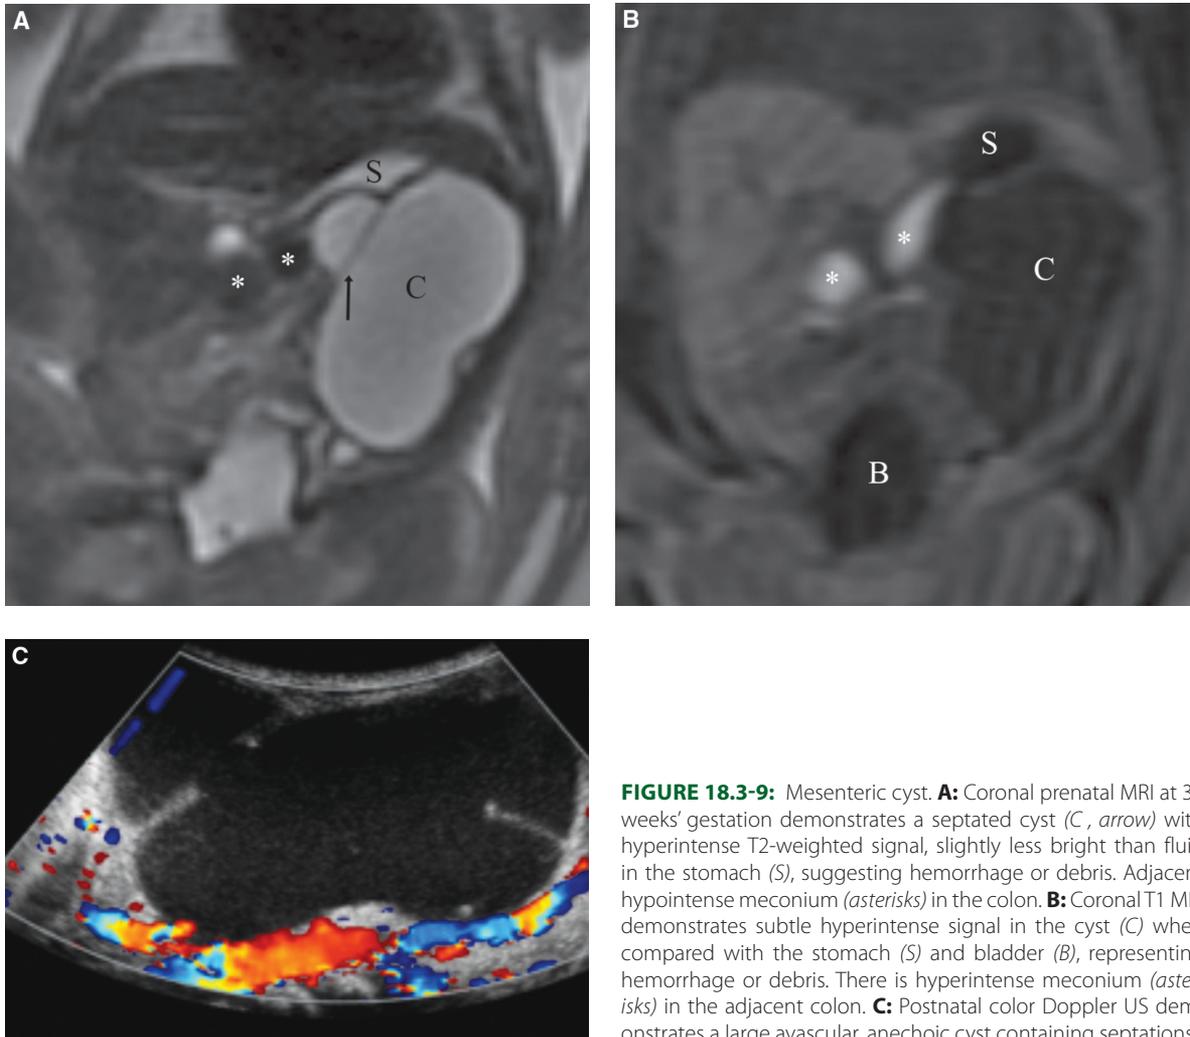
Mesenteric cyst. A: Coronal prenatal MRI at 30 weeks' gestation demonstrates a septated cyst (*C*, *arrow*) with hyperintense T2-weighted signal, slightly less bright than fluid in the stomach (*S*), suggesting hemorrhage or debris. Adjacent hypointense meconium (*asterisks*) in the colon. B: Coronal T1 MRI demonstrates subtle hyperintense signal in the cyst (*C*) when compared with the stomach (*S*) and bladder (*B*), representing hemorrhage or debris. There is hyperintense meconium (*asterisks*) in the adjacent colon. C: Postnatal color Doppler US demonstrates a large avascular, anechoic cyst containing septations.
